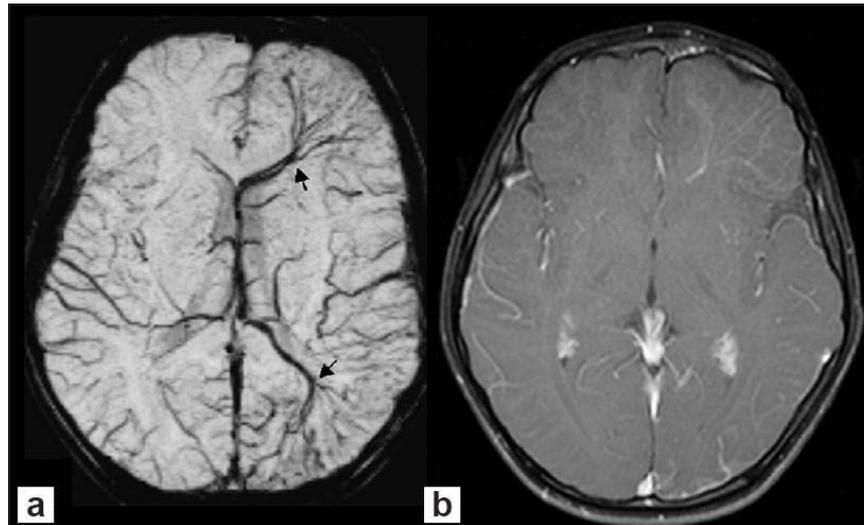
Example SWI scans: (a) shows cortical veins draining into enlarged transmedullary veins (black arrows), which are difficult to see on the contrast-enhanced T1-weighted axial image (b) [<http://www.neurology.org/content/71/5/382/F1.expansion.html>, accessed on 15/04/2013].
